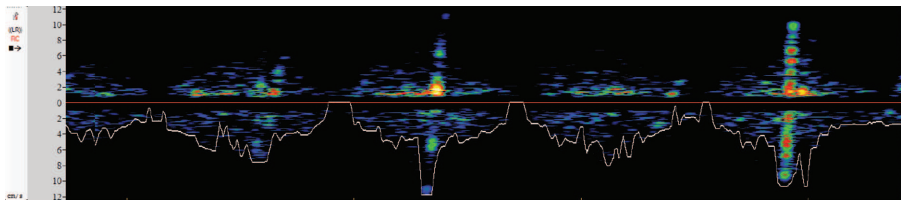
8-MHz CCUS probe spectral Doppler recording of passing bubbles during pulsatile flow profile.
